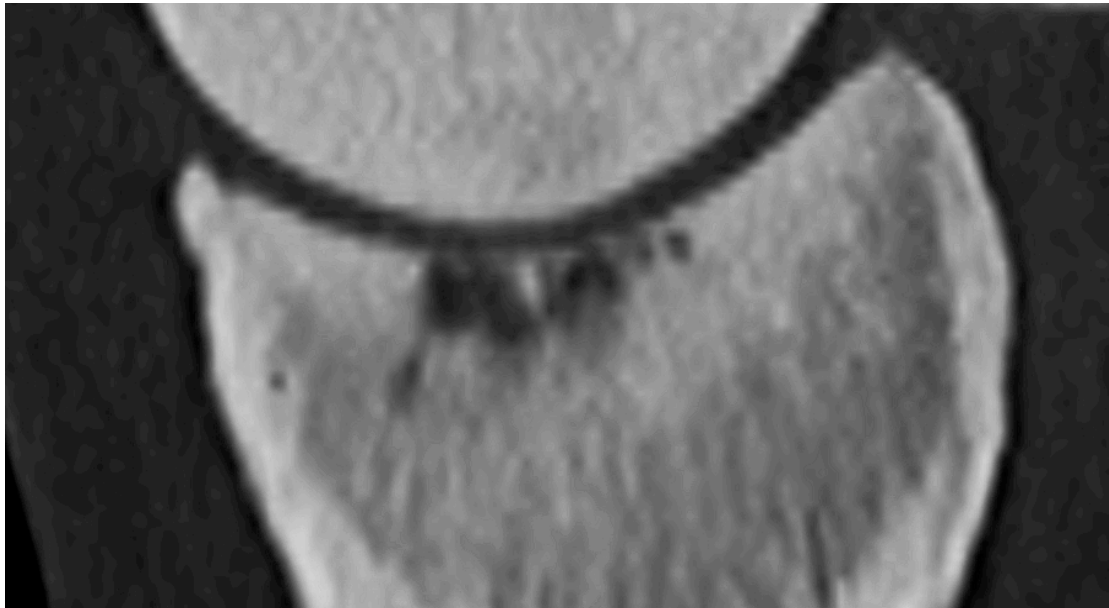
Sagittal CT view of the same SCL showing heterogeneous content and mild sclerosis.
